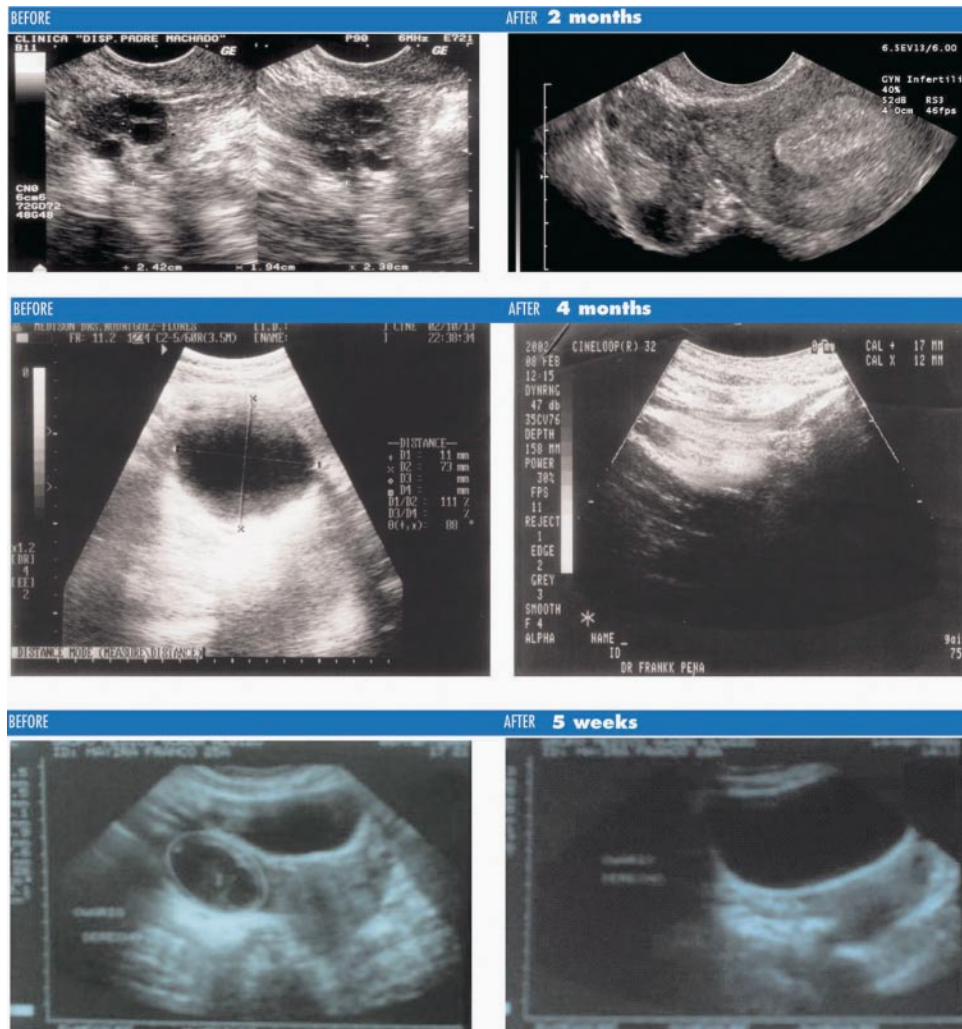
PCOS before/after echosonographic comparison. Interval between echosonograms: 2 months.
